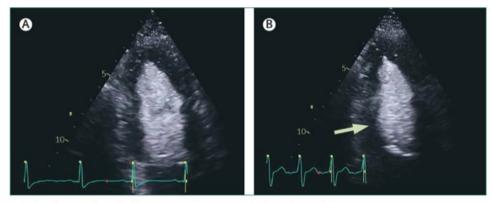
Pharmacological (dobutamine) contrast stress echocardiography
